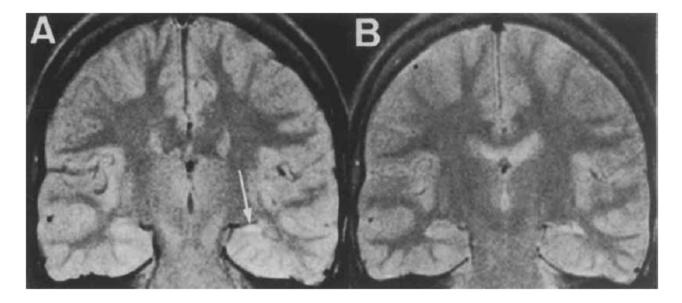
Magnetic resonance imaging, Patient 10. (A) First echo image. The left bippocampus (arrow) is severely shrunken with slightly increased signal compared with the left. (B) Second echo image. The asymmetry in the hippocampal signals is better appreciated; the abnormal left hippocampus can be resolved from the adjacent high signal of the temporal horn.
